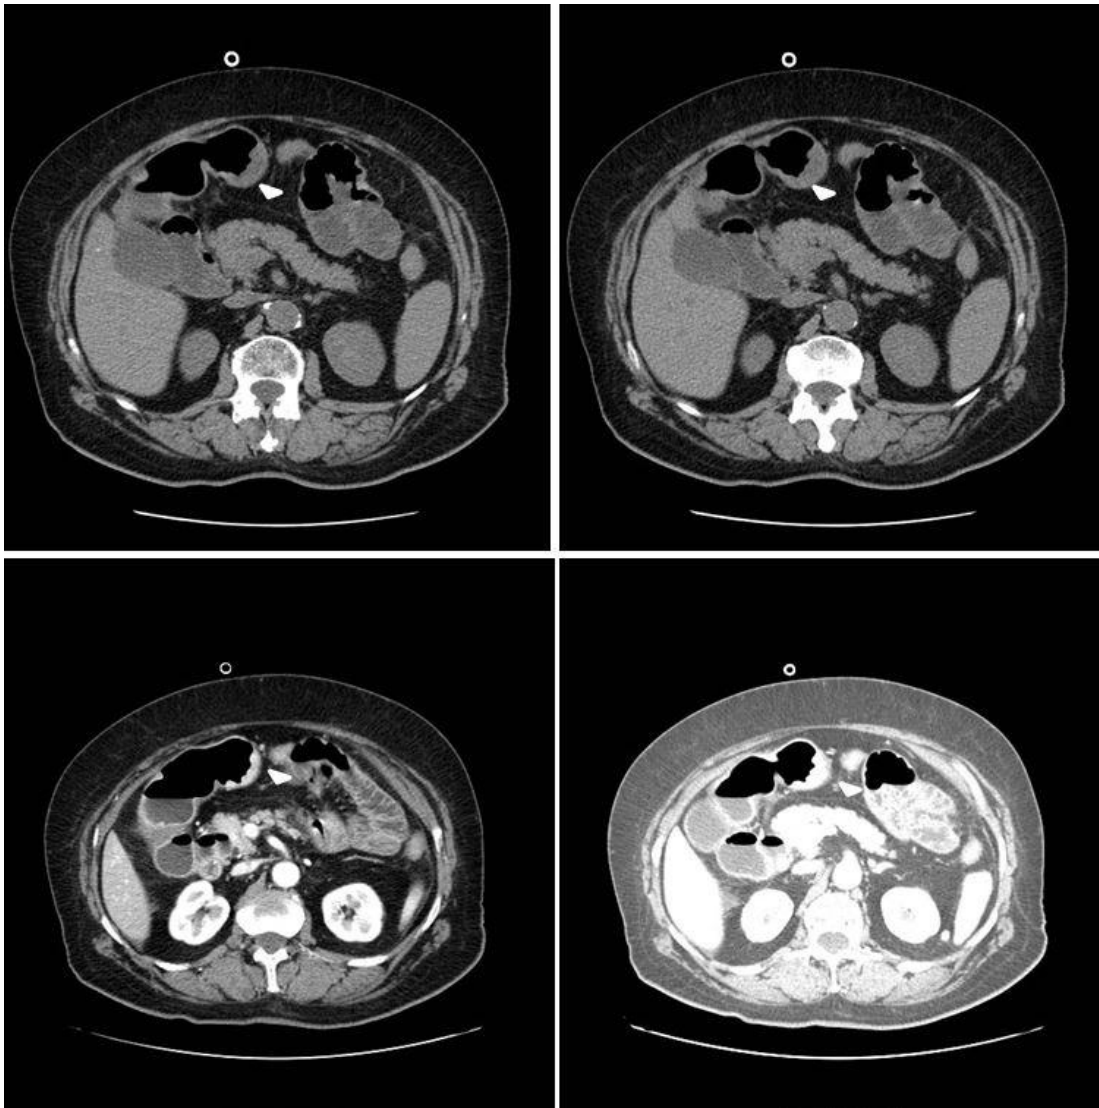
Preoperative CT scan with identification of fusion fascia of Fredet (arrows) in correspondence of the duodenum-pancreatic area.
